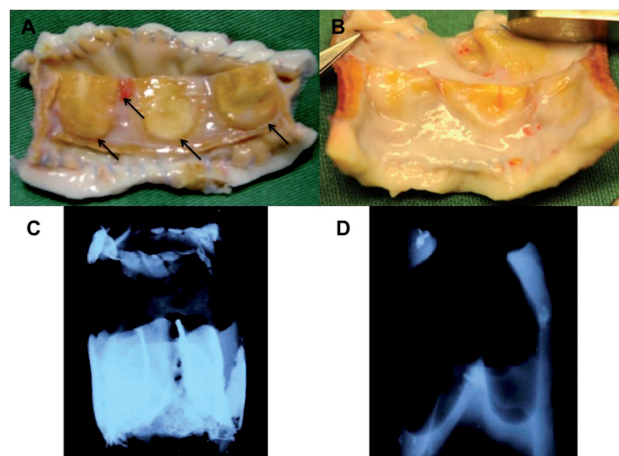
Macroscopic analysis. Gross macroscopic and radiographic aspects of the grafts. In A, the GDA valved conduit with calcified cusps (arrows), confirmed by radiography, in C, showing cusp calcification, in B, DESCEL valved conduit with preserved cusps without gross calcification (arrow), and, in D, only calcification spots in suture lines
